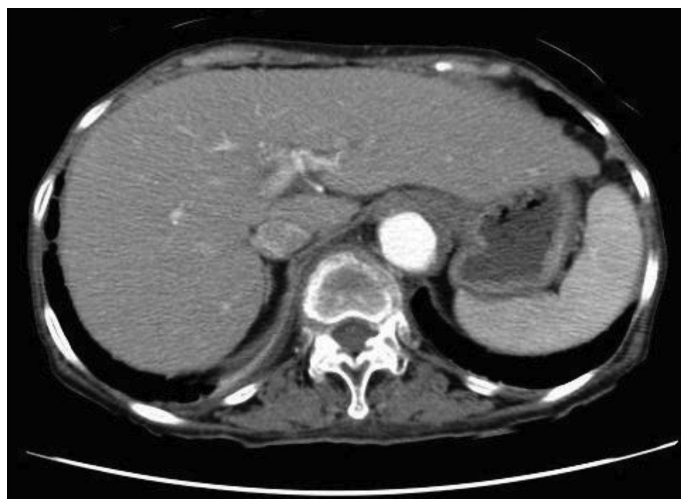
Axial contrast-enhanced computed tomographic scan obtained on postoperative day 10. No leakage was found and the hematoma had become absorbed.
